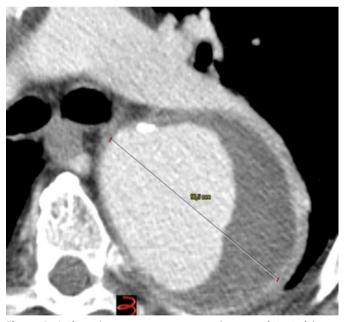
A thoracic aneurysm sac expansion was detected in an emergent CTA
